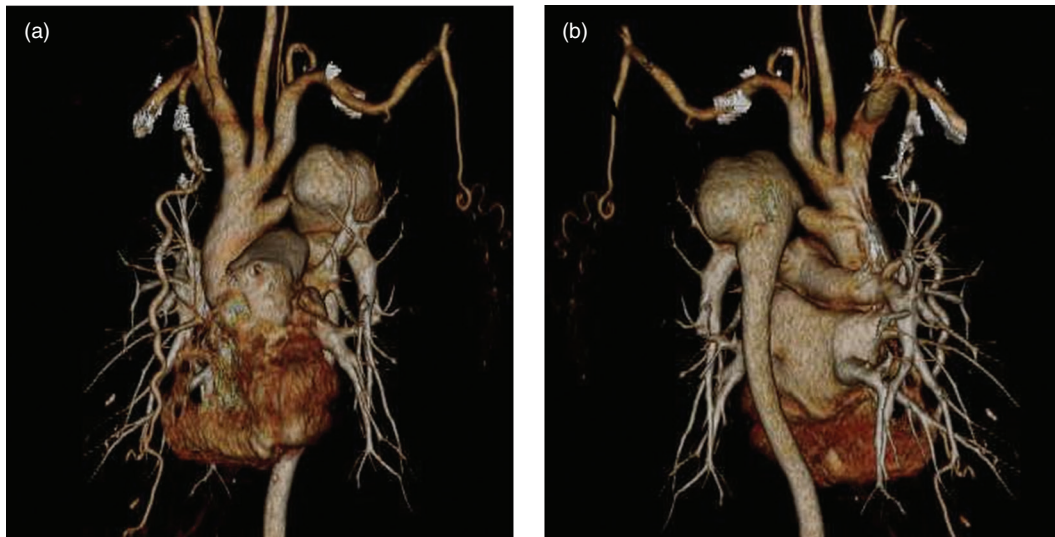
(a) Anterior preoperative three-dimensional computed tomography (3D-CT). The cervical vessels and the fifth aortic arch branch separately from the ascending aorta. The stenotic lesion in the fifth part of the aortic arch is located just proximal to the aneurysm. (b) Posterior preoperative 3D-CT. The saccular aneurysm of distal aortic arch reaches 55 mm in greatest diameter.
